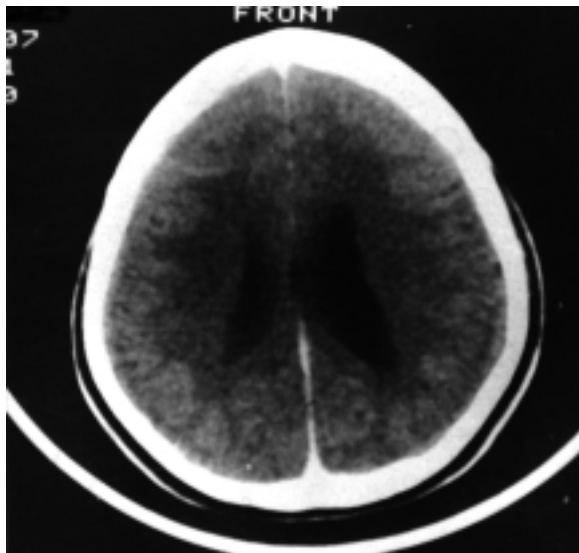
Followup contrast CT scans shows complete resolution of the granuloma.
